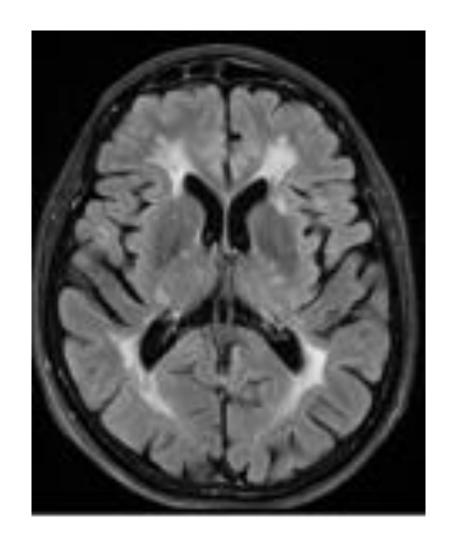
Demyelination process and MS lesion by MRI.
